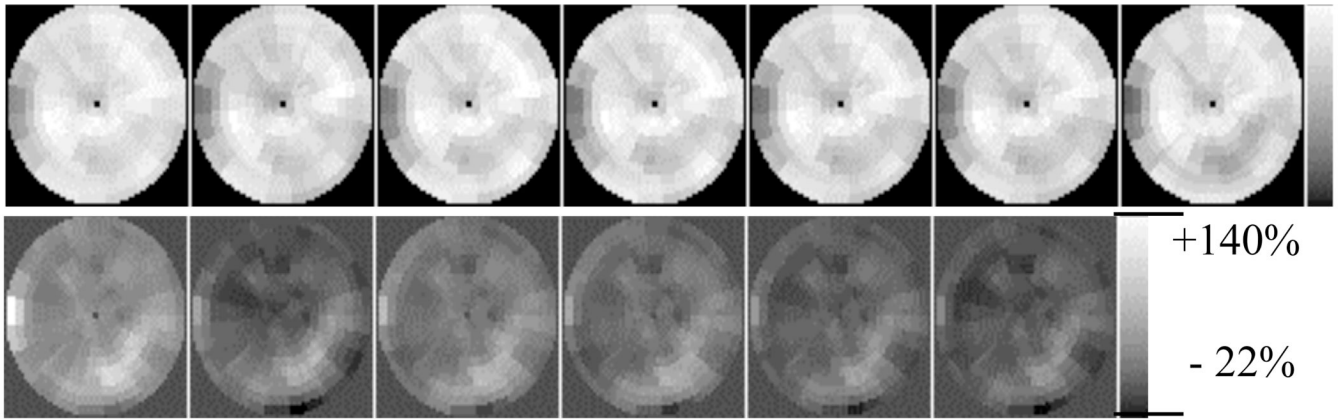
Polar maps (top row) and relative error polar maps (bottom row) corresponding to the images shown in Figure 9 (from left to right): no cross-talk compensation, TWC, SimMBC without x-ray model, SimMBC with x-ray model, SeqMBC without x-ray model, SeqMBC with x-ray model, and ‘no cross-talk’ image. The polar maps on the bottom row are displayed as percent error relative to the ‘no cross-talk’ polar map.
